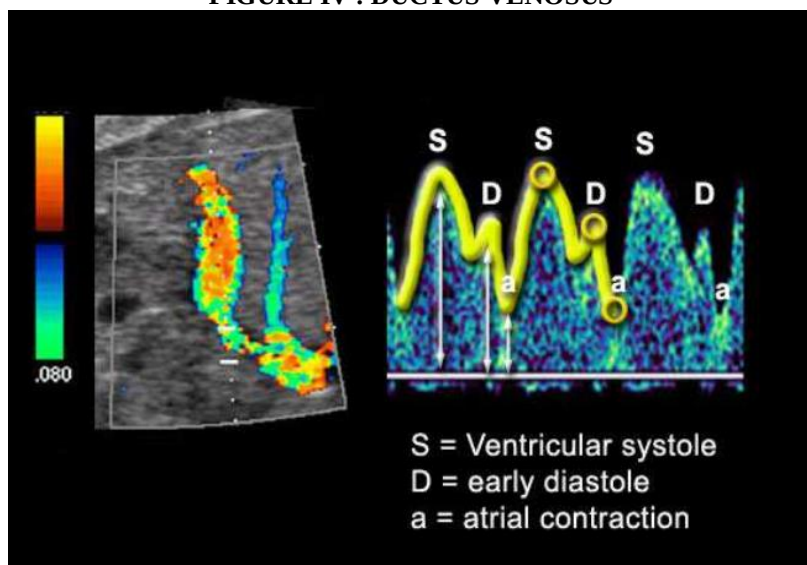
FIGURE IV A : Colour Doppler image and waveform of ductus venosus.
